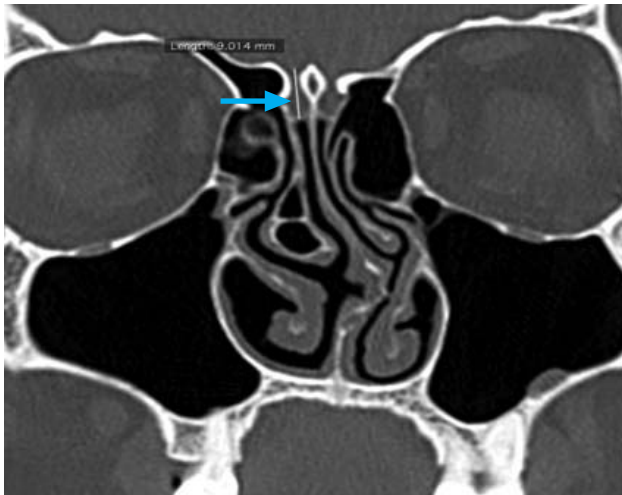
Coronal view of CT PNS: Depth of olfactory fossa measures about 9.0 mm and falling under Kero's type III classification
